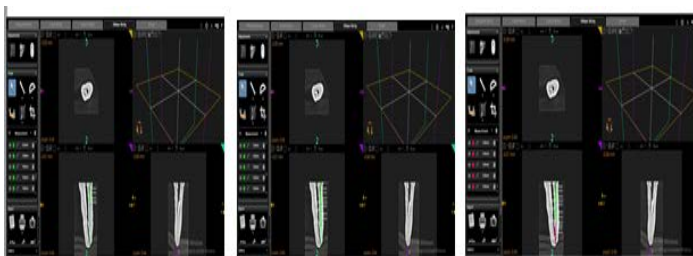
(a), (b), (c): Showing the Post-CBCT measurements of remaining gutta percha in the coronal, middle, apical portion using RECIPROC respectively
